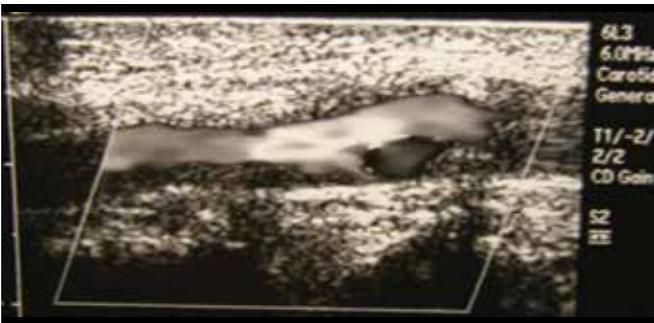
Carotid duplex ultrasound indicating severe atherosclerosis/stenosis of left carotid artery.
